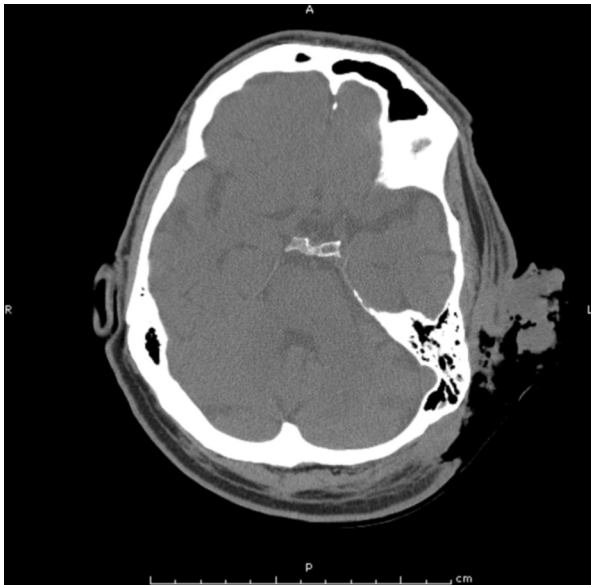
Computed tomography scan of a 73-year-old male with an irregular lesion arising from external auditory canal consistent with visualized cutaneous lesion and live maggots.
